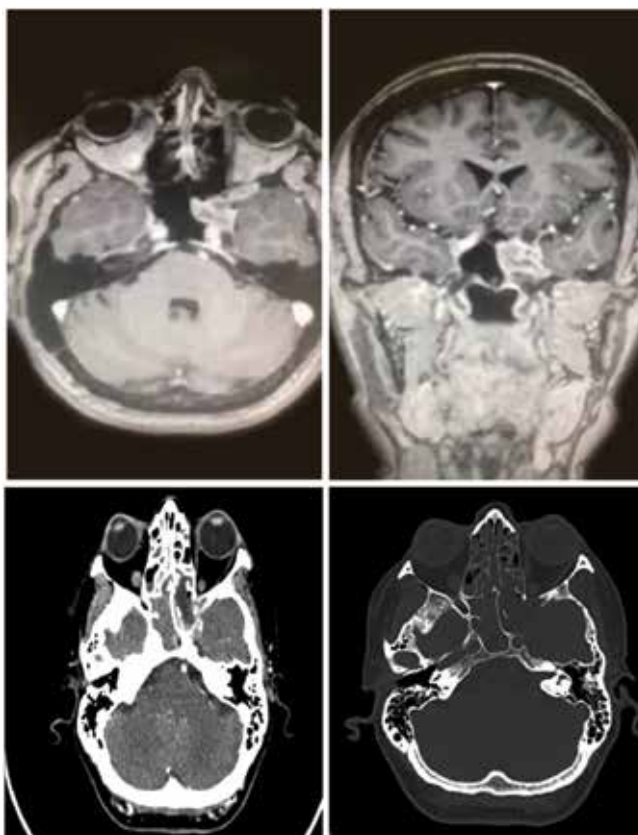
From the left to the right: T1 gadolinium enhanced TS. The patient underwent endoscopic transpterygoid endonasal approach for an anteromedially located trigeminal schwannoma. In the middle, postoperative CT scan, and bone scan on the right show nuances of the approach and gross total resection of the tumor.
